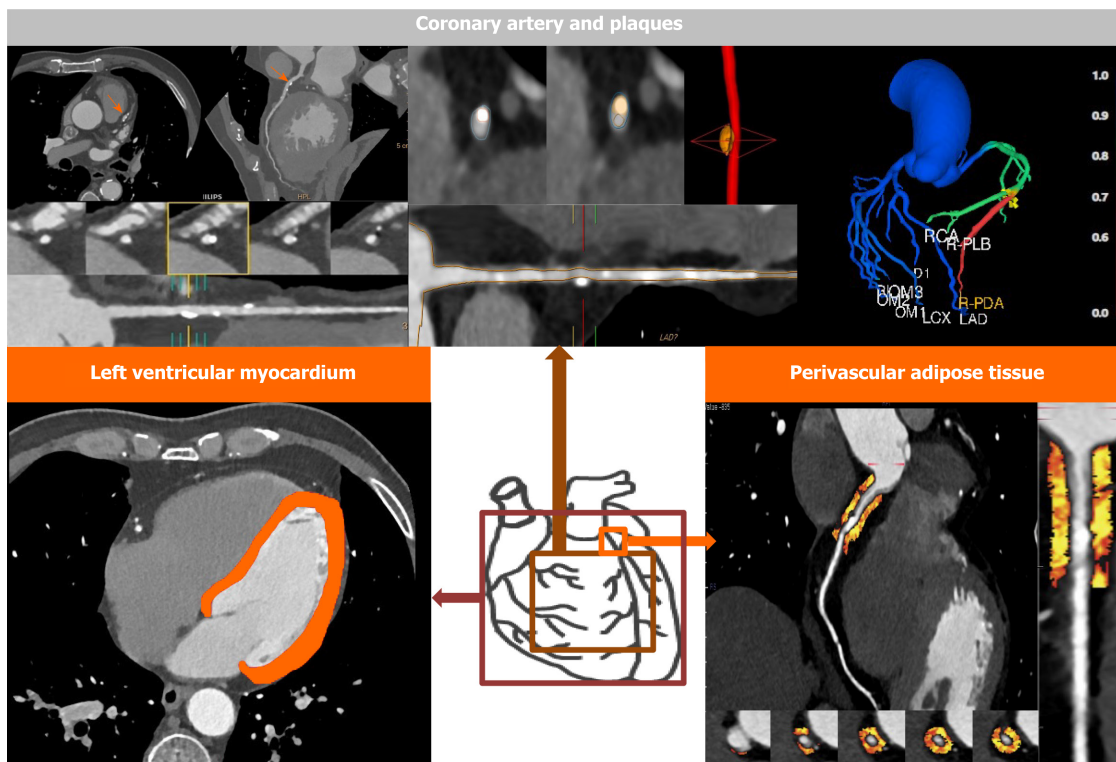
The application of artificial intelligence in coronary computed tomography angiography.
